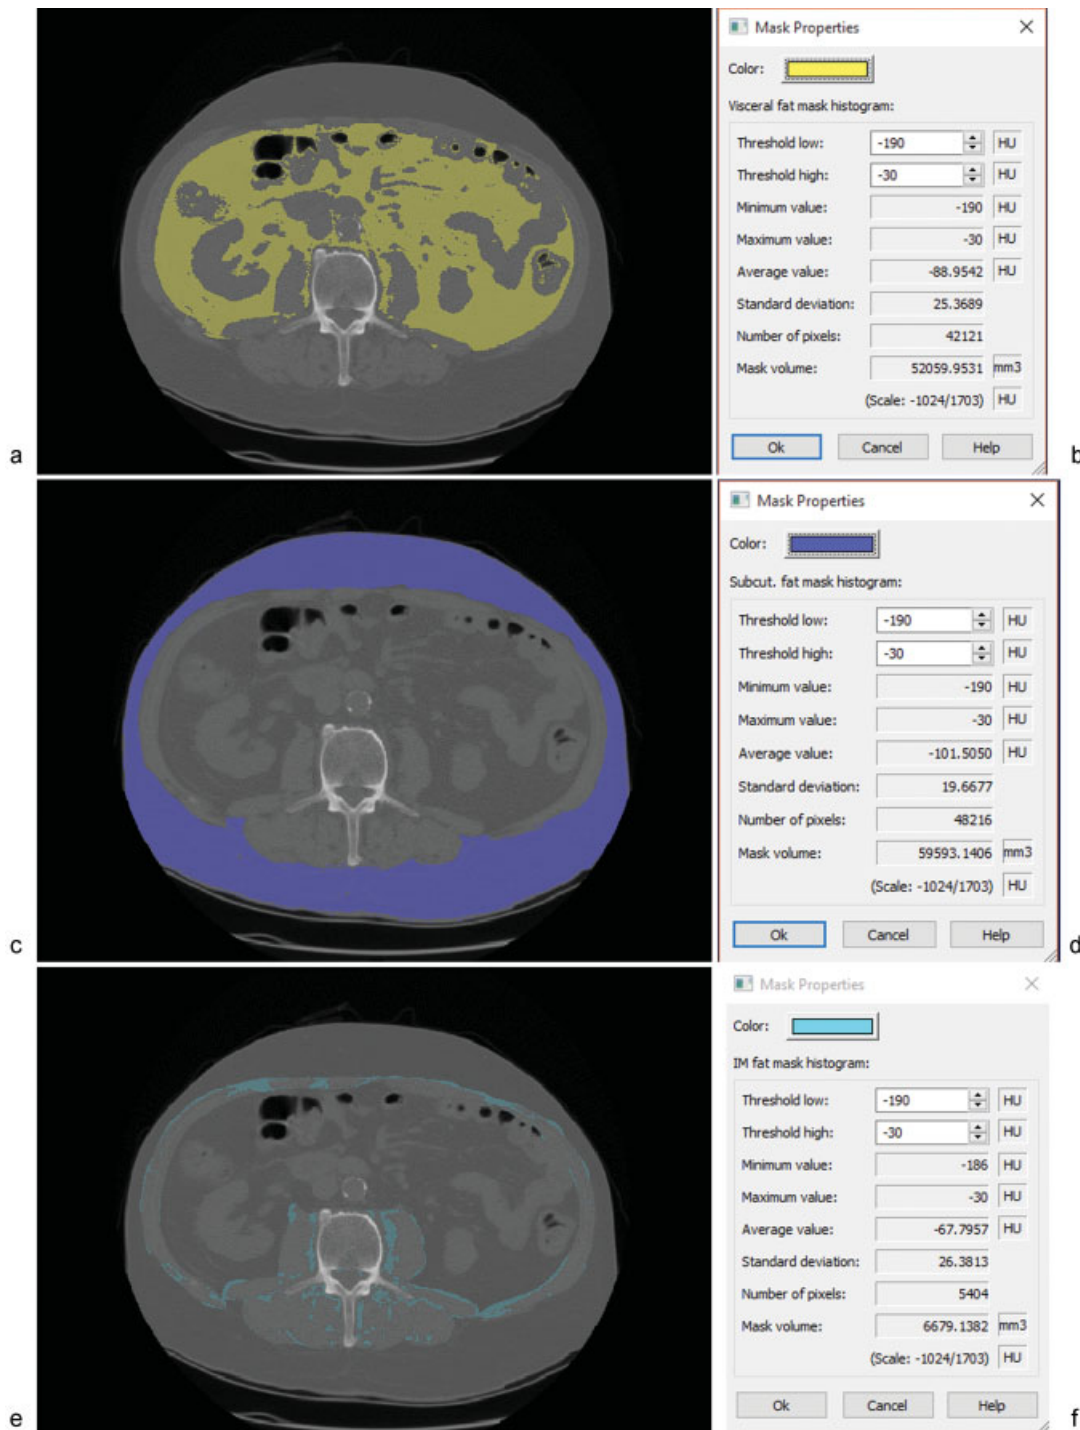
A 65-year-old woman presents for sarcopenia evaluation. Computed tomography images at L3 show (a, b) visceral adipose tissue (VAT), (c, d) subcutaneous adipose tissue (SAT), and (e, f) intermuscular adipose tissue (IMAT) segmentation using the -190 to -30 HU thresholds.
